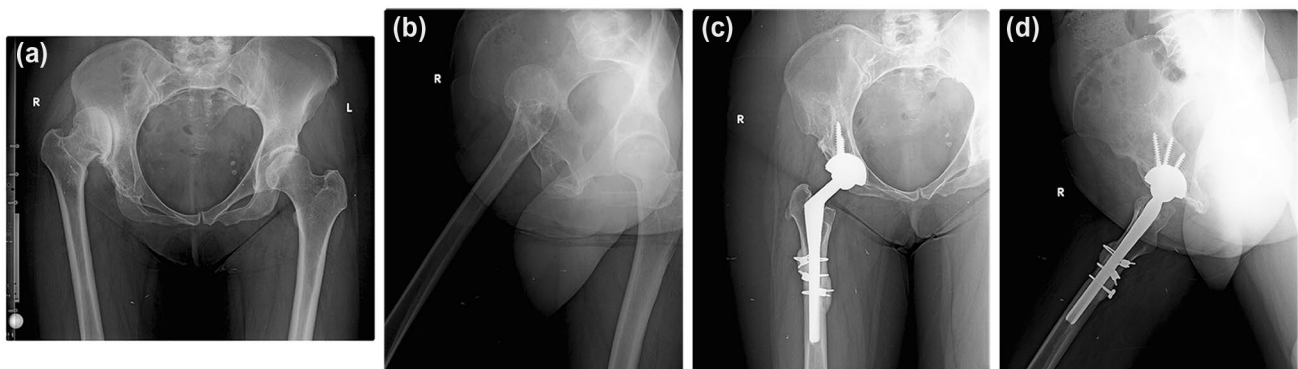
a Preoperative AP radiograph of 45-year old female with high congenital dislocation, Crowe type 4. b Lateral radiograph of of 45-year old female with high congenital dislocation, Crowe type 4. c
